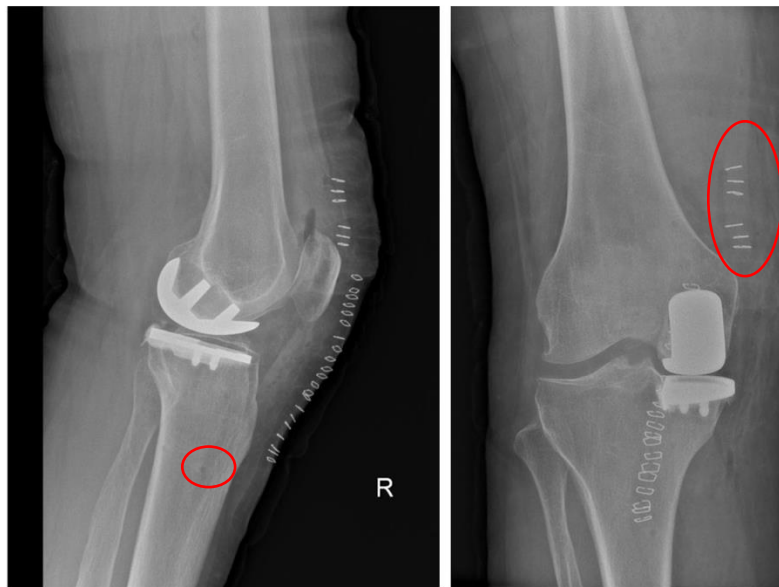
Example of post-operative radiography in robotic-assisted UKA. In the left image, the drilled proximal tibia when collocating the robot's trackers is marked in red. In the right image, additional staples for the accessory wound incision in the femur are marked in red.
